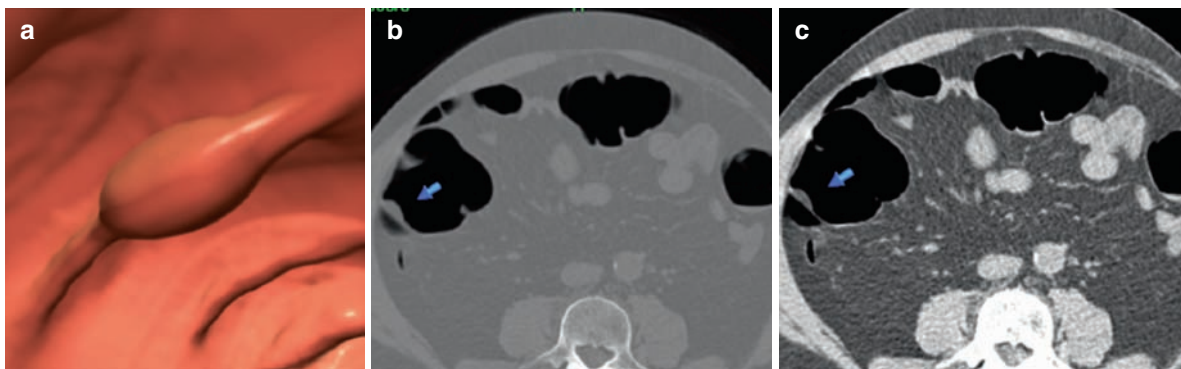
Submucosal colonic lipoma: (a) 3D endoluminal view of the colon and (b) axial CT image with: window settings show a 12 mm lesion in the ascending colon; (c) axial
